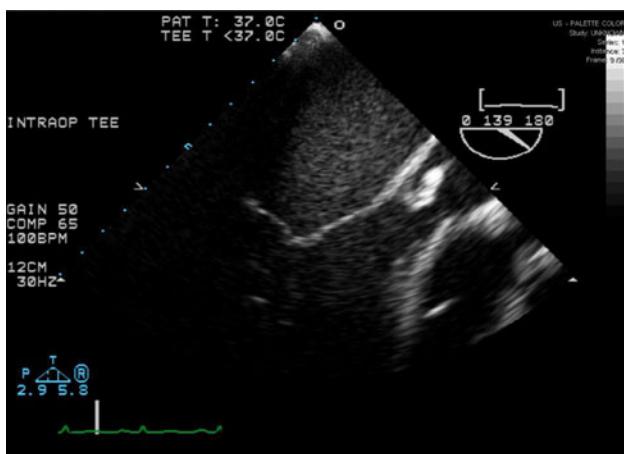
Transesophageal echocardiograph shows septic vegetations over the aortic valve cusp
